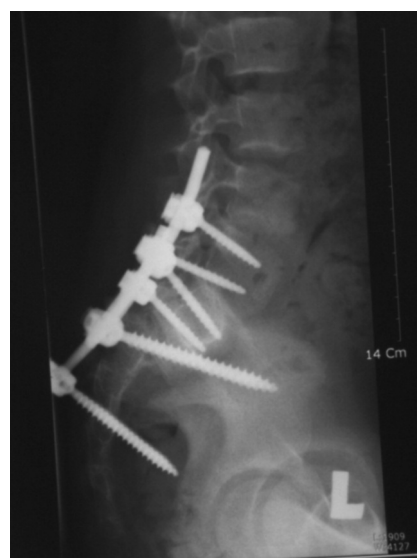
Radiograph showed limited reduction of S1/S2 dislocation stabilised by lumbopelvic fixation.
